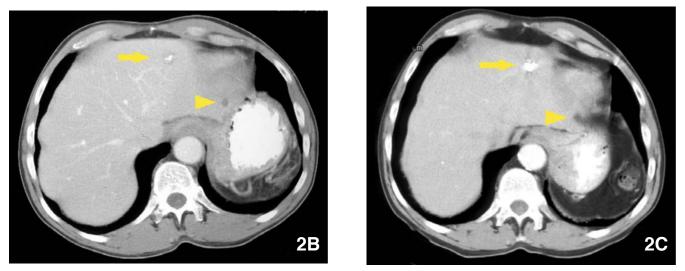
CT images at the level of a left lobe liver metastasis (arrow) and small incidental cyst (arrowhead). B. At 30 months after transplant with decreasing size and central calcification within the metastasis. C. At 42 months after transplant with complete calcification of the metastasis.
